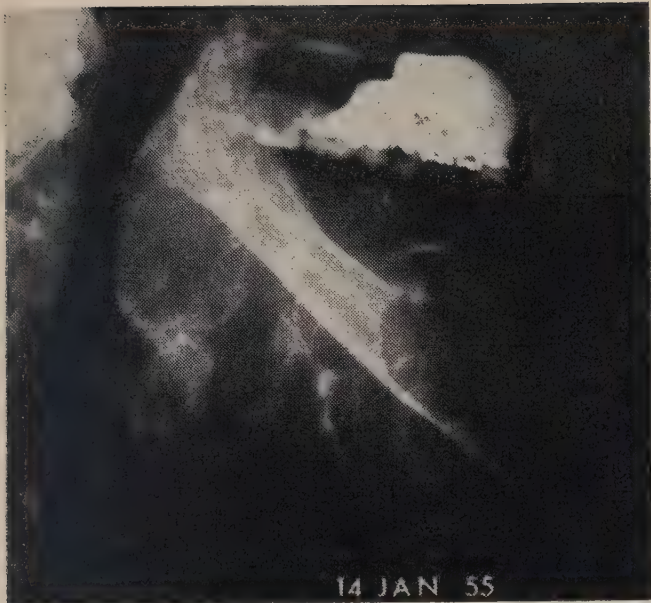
Radiograph of lesion in January 1955, just prior to surgery.
